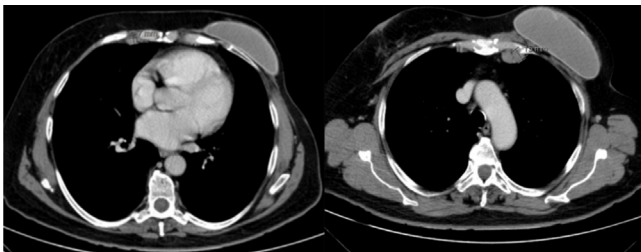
Contrast computed tomography scan (coronal plan): lymph nodes in both internal mammary chains, the biggest one on the left side with 15 mm.
